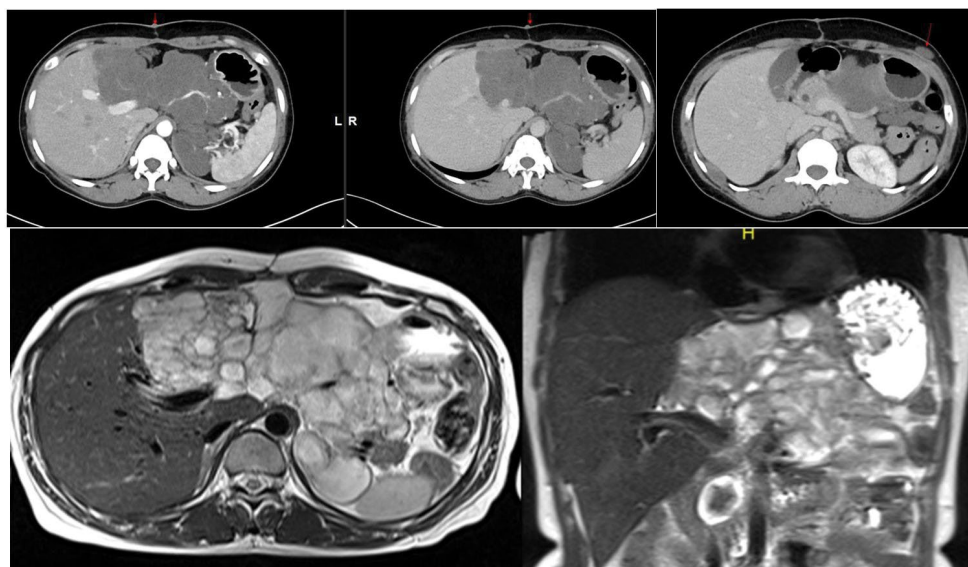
Plexiform NF of liver. (a,b) Contrast enhanced CT axial sections shows a large, irregular lobulated soft tissue dense lesion in perivascular distribution with preservation of the vessels showing no significant enhancement in epigastric region involving the left lobe of liver. Left branch of portal vein not separately made out, possibly thrombosed. Left branch of hepatic artery seen coursing through the lesion. Lesion abuts the lesser curvature of stomach, pancreas and spleen with no obvious infiltration. (c) Small soft tissue dense nodular lesion seen in the subcutaneous plane of anterior abdominal wall (↓); (d,e) MRI-T2 axial (a) and T2 HASTE (b) coronal sections shows heterogeneous predominantly T2 hyperintense macronodular lesion involving the left lobe of liver. Flow voids of left branch of portal vein not seen, suggestive of thrombosis.
